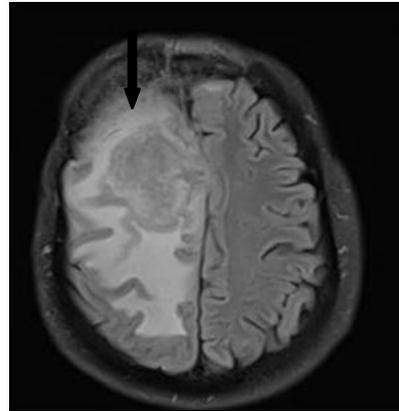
MRI brain of the lesion showing an ill-defined, peripheral enhancing lesion (White arrow) with central necrosis in post-contrast, T1-weighted sequence. The genu of the corpus callosum was also enhanced (Red arrow)—the lesion iso-intense (Black arrow) in the T2-weighted sequence, surrounded by extensive, vasogenic edema.
